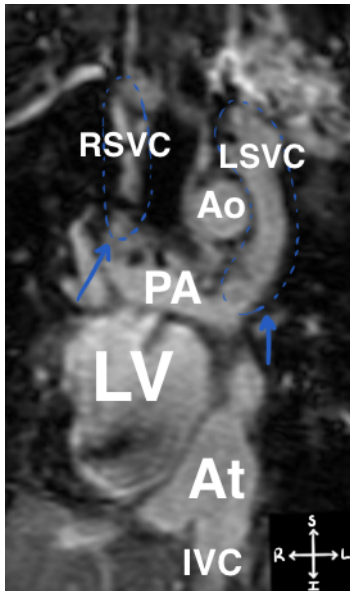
MRI scan of a heart of a patient with complex CHD. It shows the presence of two venae cavae (blue circles and arrows). Coronal view.
